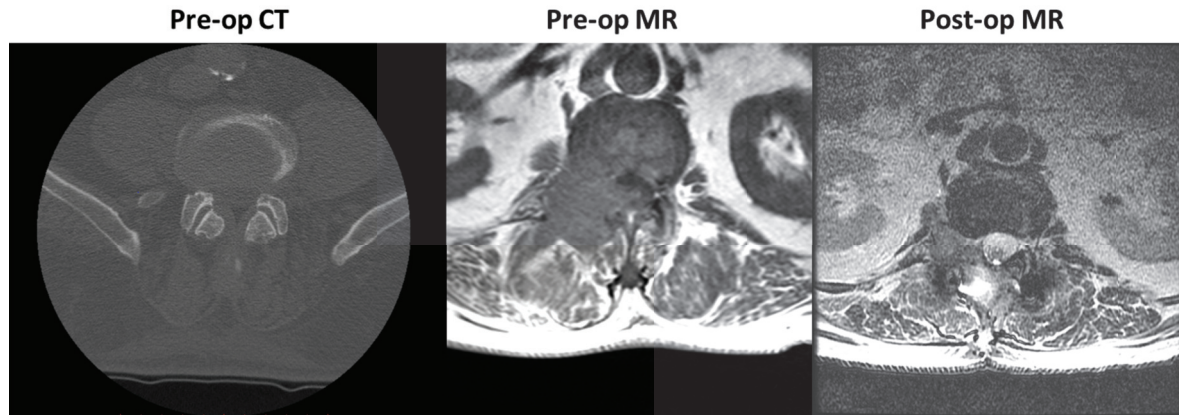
Patient 4: Clinical course – Patient with L2 mass measuring 11 cm. Pre-operative MRI shows soft tissue lesion extending into the L2 spinal vertebral body and obliterating the R L2 pedicle. Postoperative changes seen on MRI with right semicircular epidural disease with minimal compression on the thecal sac.
